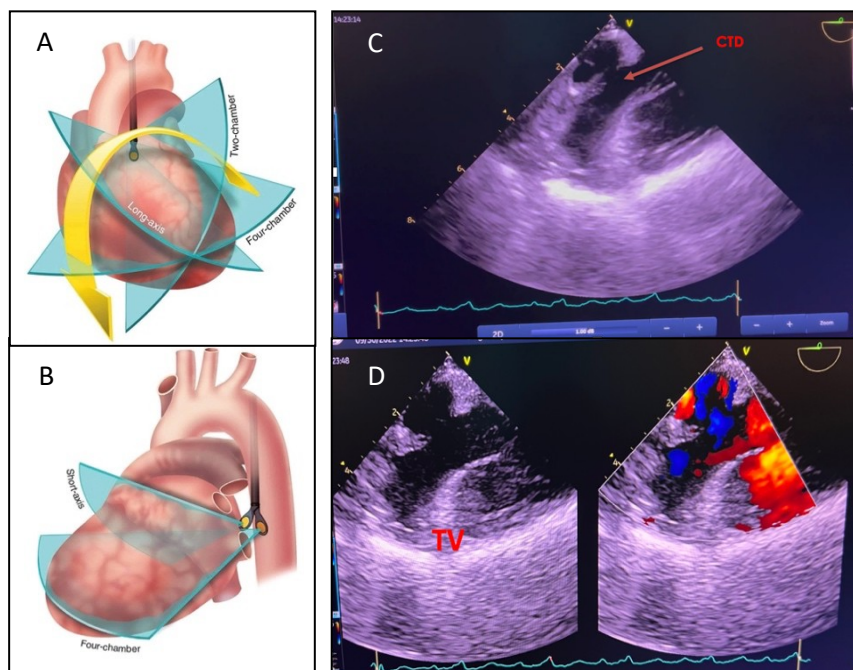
Transesophageal Echocardiography A. Image plane in relation to the TEE probe B. Position of the probe in relation to the heart, visualized here are the posteriosuperior portions of the interatrial septum and the right atrium (Otto, C. M. (2018) C. An incomplete membrane from the superior portion of the interatrial septum to the superoposterior wall of the right atrium which highly defined a Cor Triatriatum Dexter. D. Color Flow Doppler showing color flow between the right atrium and the superior chamber formed by the incomplete membrane with no significant gradient between the two chambers.
